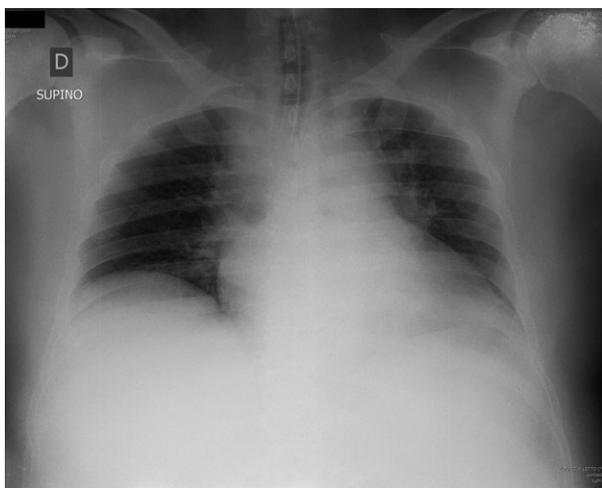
Chest radiograph of the donor.
